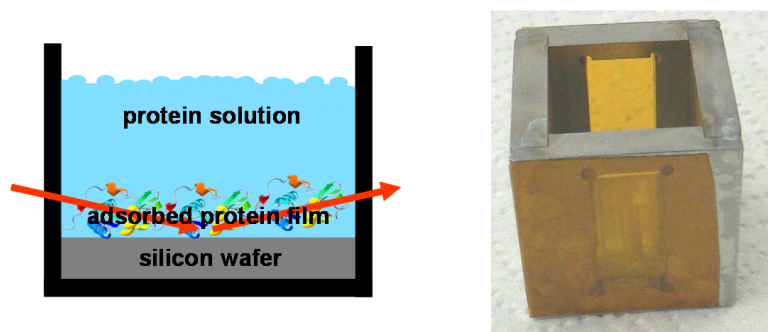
(Left) Sketch and (Right) photo of the common sample cell for the study of solid-liquid interfaces at beamline BL9 (DELTA). The volume of the sample cell is about 10 mL, the path of the X-ray beam through the cell is approximately 30 mm.
